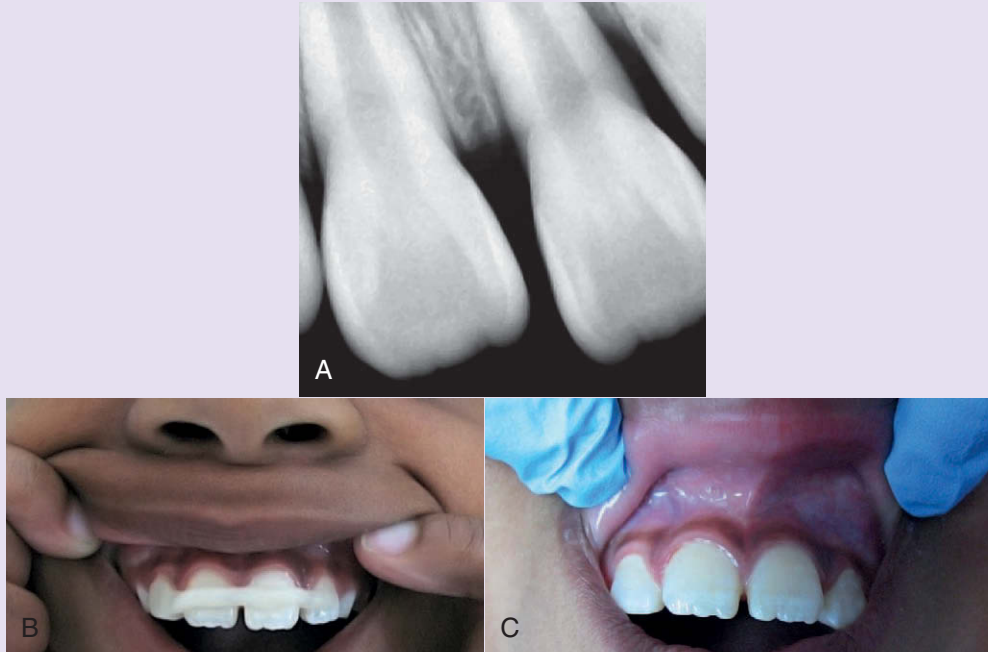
• Partially avulsed permanent incisor. A, Preoperative radiograph. B, Tooth splinted and treated with low-level laser 1 minute over lingual and facial areas. C, Tooth remains vital 23 months after treatment.
